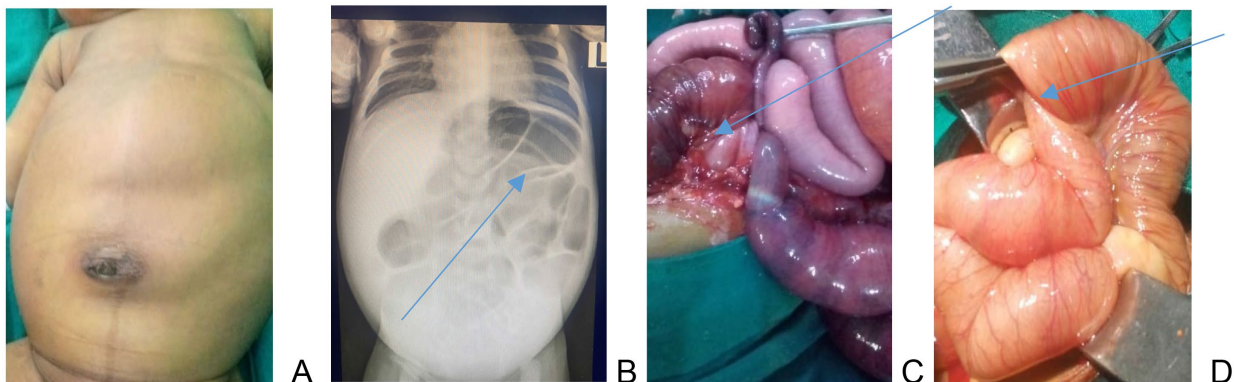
The distended abdomen, X-ray film with airfiled levels, ischemic bowel loop with bands and resolved ischemic telescopic loop after band release in (A), (B), (C) and (D) respectively.
